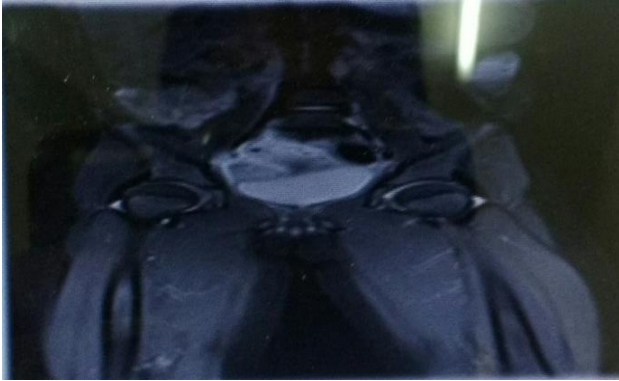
MRI (abdomen and pelvis): shows right side tubo ovarian torsion.
